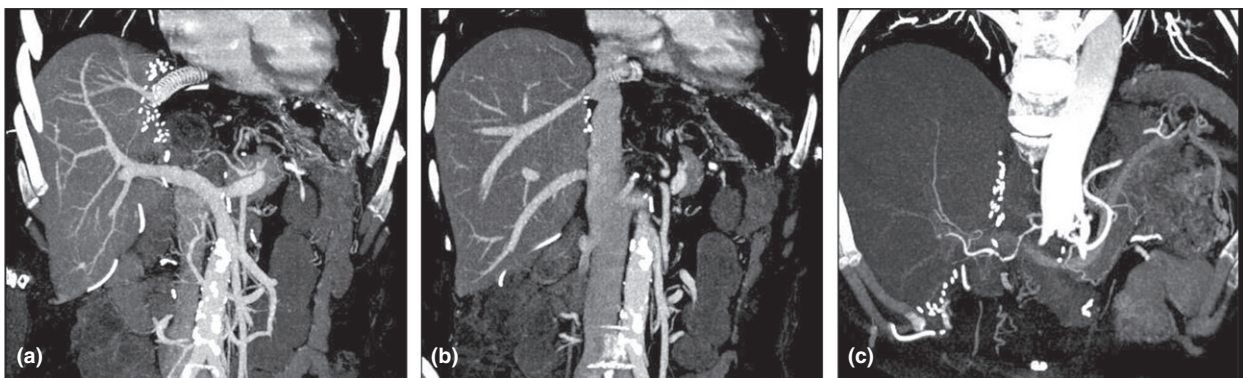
Follow-up computed tomography (CT) scan on post-transplantation day 21. The photographs showed good patency of reconstructed vascular structures including portal vein (a), right hepatic vein and inferior hepatic vein (b), and hepatic artery (c).
